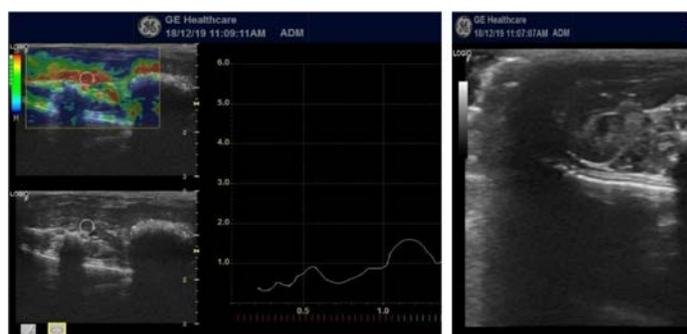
Elastography and Ultra sonography of 500. Liver size: 1.8cm. Elastographicscore(pKa-2.3)
